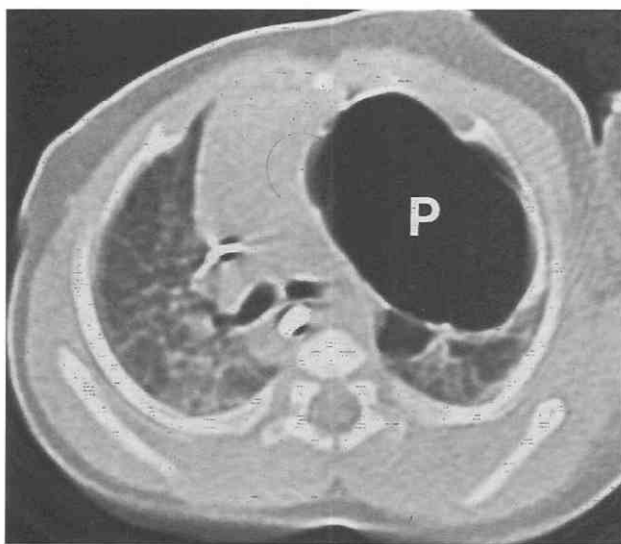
Pneumatocele in a 3-month-old boy. CT scan shows large air-filled cavity (P) with thin walls in the left upper lobe. The surrounding lung parenchyma demonstrates no evidence of necrosis.
